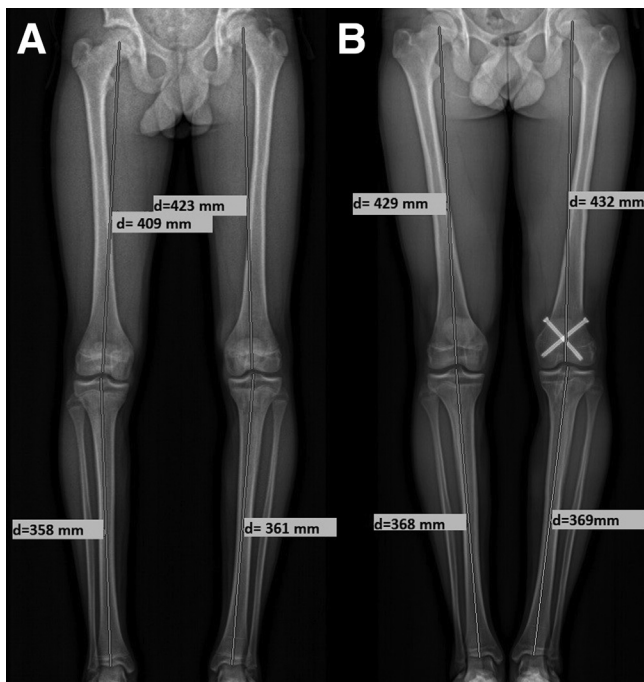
Management of the overgrowth of 1.82 cm. (A) EOS radiography showing overgrowth prevailing on the left femur. (B) EOS radiography after distal left femoral epiphysiodesis with 2 screws at the last follow-up showing good recovery of the length. (d, distance.)
